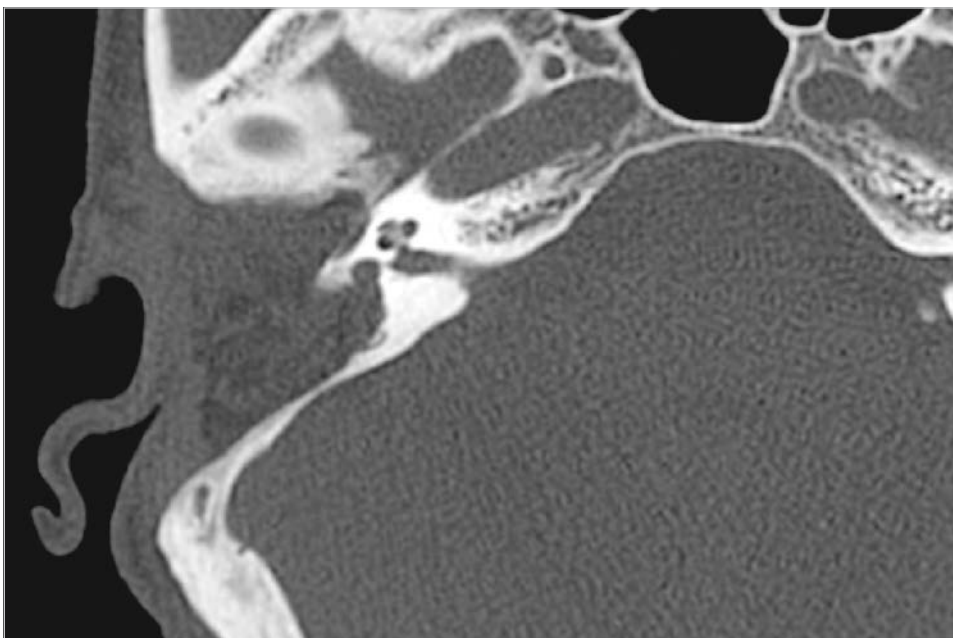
The postoperative CT shows complete removal of the posterior labyrinth. Because of limited extension of the cholesteatoma, thin bone covering the posterior fossa dura is remained at this level.
